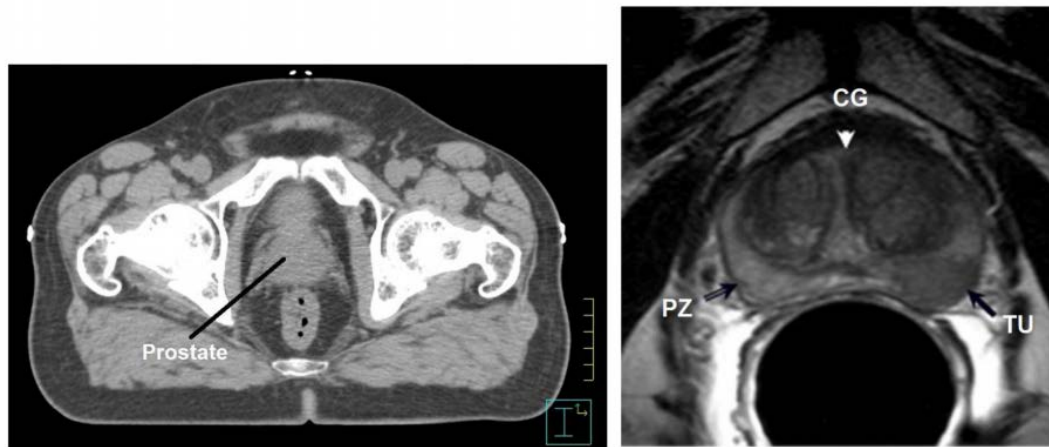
1: Comparison of axial CT (left) and T2-weighted MR (right) images to depict
